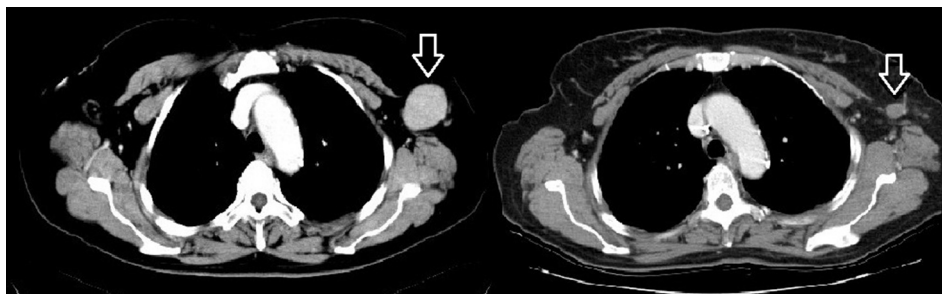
The computed tomography (CT) image of a shrunken metastatic axillary mass after additional concurrent chemoradiotherapy (CCRT), following ICRT with picibanil (OK-432) and human papillomavirus (HPV) 6, 11, 16, 18 recombinant vaccine (Gardasil; Merck and Co., Inc. Kenilworth, NJ, USA).
